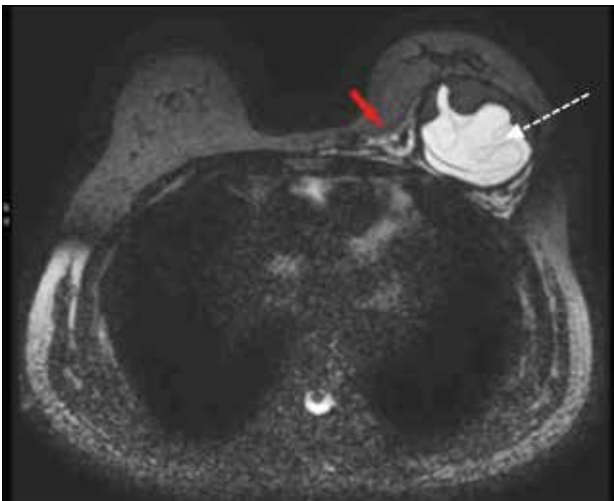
Silicone-only axial magnetic resonance imaging showing free silicone at the thickened peri-glandular stromal tissue extending to the midline and the left pectoralis muscle, representing extracapsular rupture (red arrow) of a unilateral left-sided implant. Note that there is also the 'linguine sign' (dashed arrow) representing intracapsular rupture.
